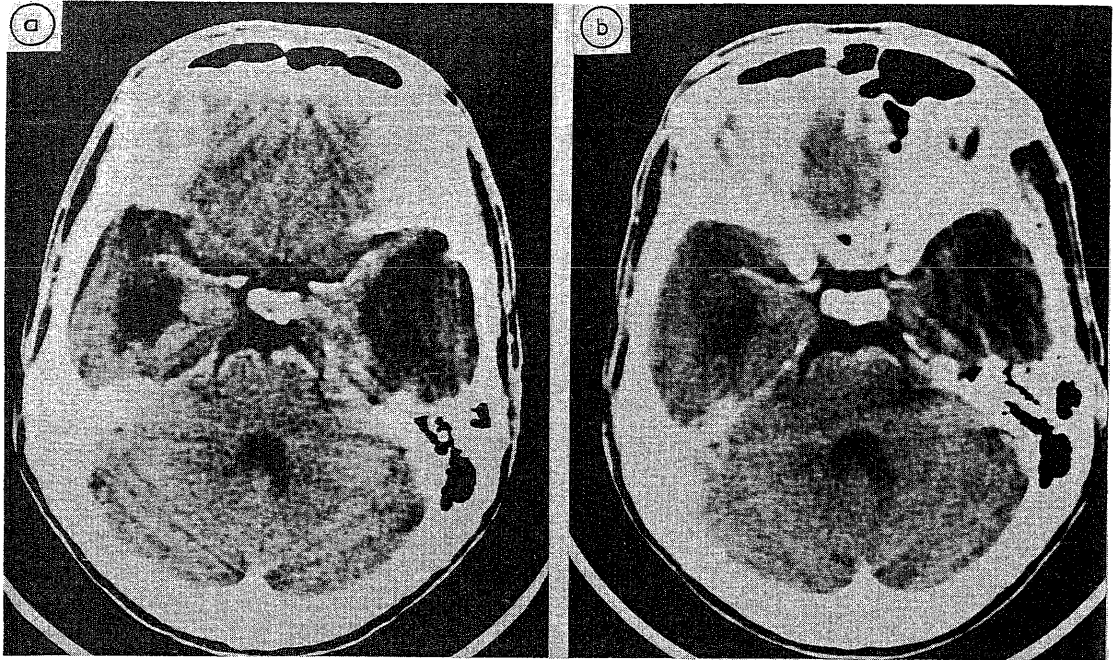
Patient 5. (A) Initial CT scan showing bilateral temporal hypodense areas, more severe on the left than right. There was no mass effect or contrast enhancement. (B) Follow-up CT scan 29 months later showed no significant change.
